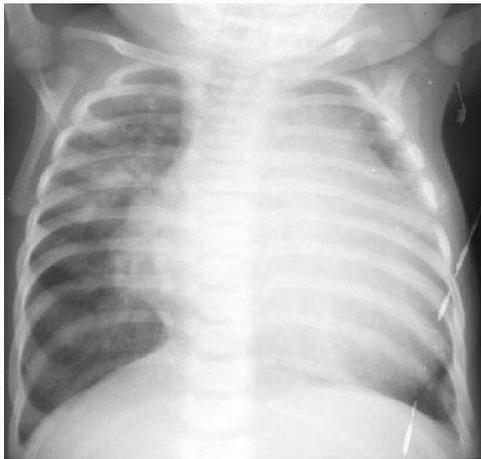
Posterior Anterior (PA): Chest X-ray demonstrates cardiomegaly, and increased pulmonary vascular markings.
